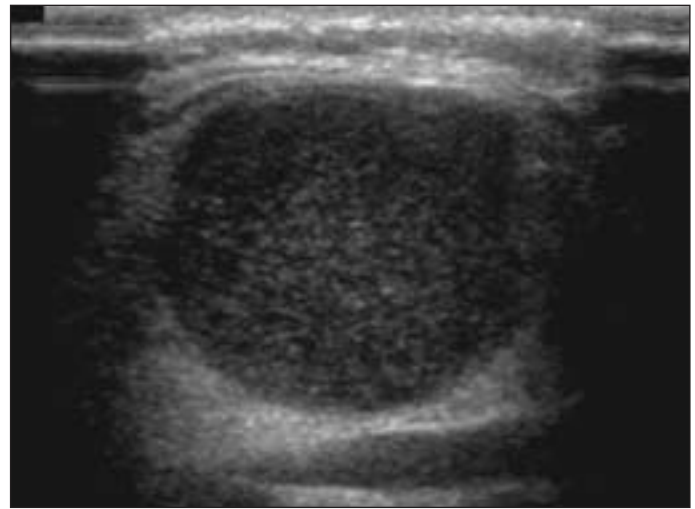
Longitudinal ultrasound of a parotid gland (same patient as Figure 2) demonstrates a circumscribed, homogenous hypoechoic lesion with distal wall enhancement. This corresponds with the area of increased positron emission tomography activity, and biopsy confirmed a diagnosis of pleomorphic adenoma.
